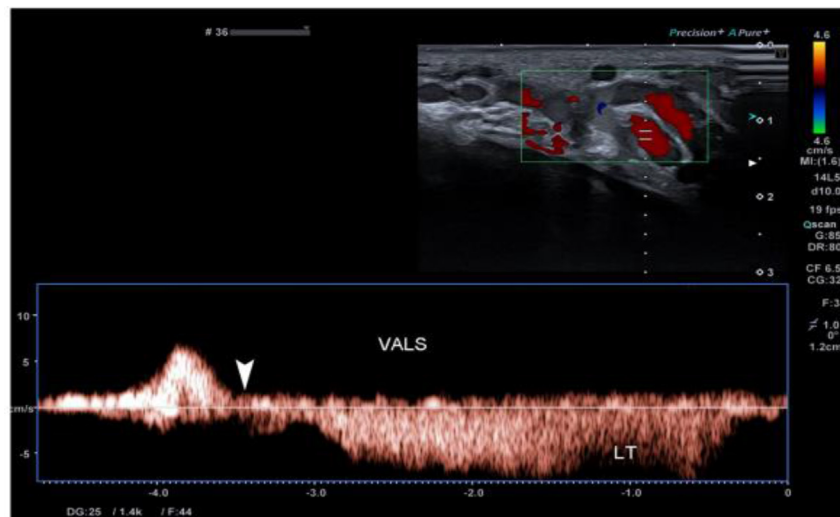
Spectral Doppler analysis during valsalva. Flow reversal demonstrated on the implementation of valsalva (arrowhead) and persisting for more than 2 s.
